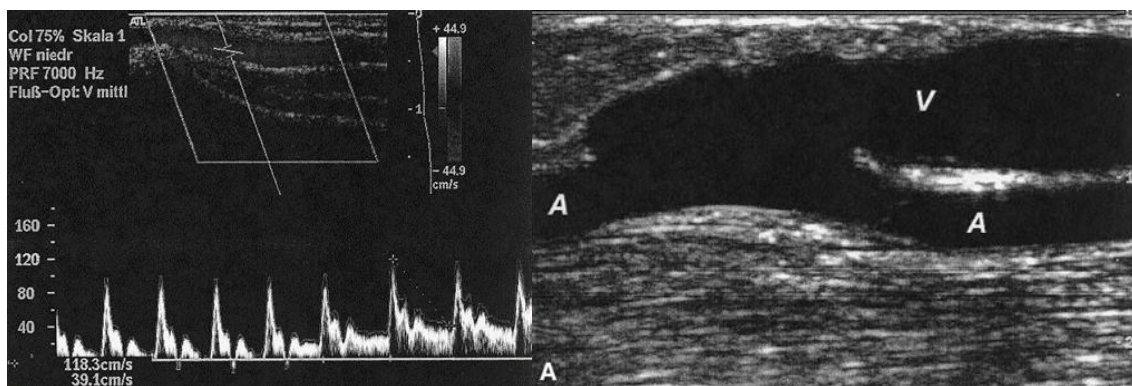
Pre-operative Ultrasound-Doppler blood velocity assessment (left); B-mode sonogram showing a longitudinal section of an AVF: vein (V) and artery (A) are detected (right). (17)
